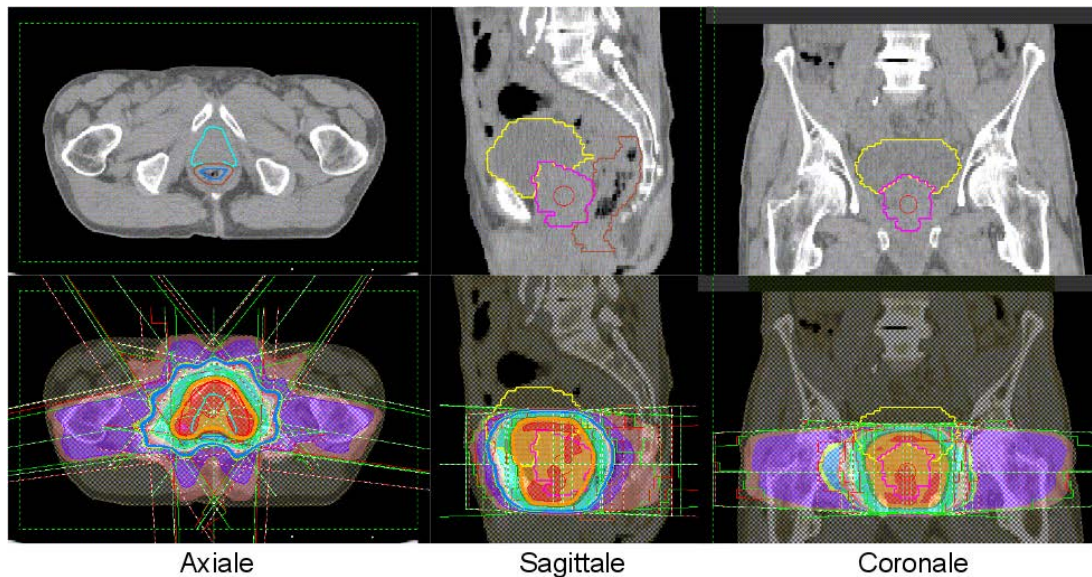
Above: Main structures (prostate, bladder and rectum) in three different views of a CT scan. Below: IMRT optimal dose distribution. Note the concave shape of the posterior part of the prostate
